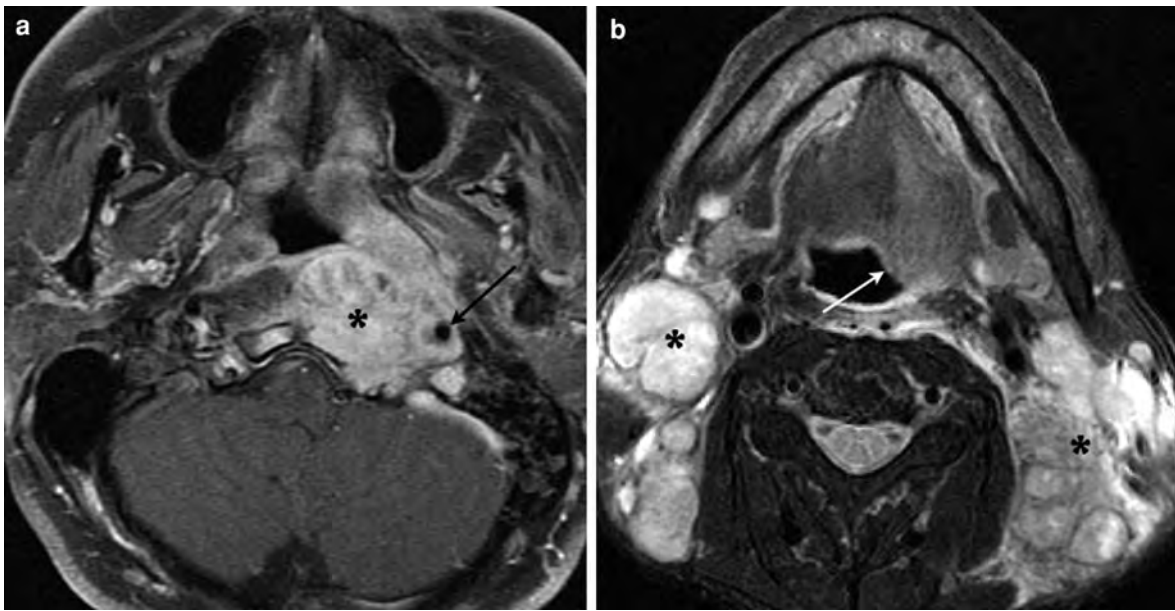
Hypoglossal denervation. a Axial contrast-enhanced fat-saturated T1-weighted MR image shows a locally advanced nasopharyngeal carcinoma (*asterisk*) extending to the left carotid space, encasing the internal carotid artery (*arrow*). b Axial fat-saturated T2-weighted MR image of the same patient shows atrophy and increased signal intensity in the left
